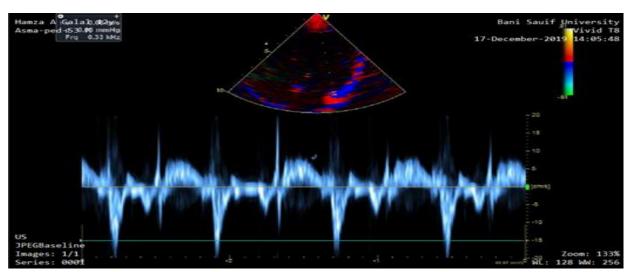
peak	systolic	velocity	of	mitral	annulus	(SM)	using	tissue	doppler
